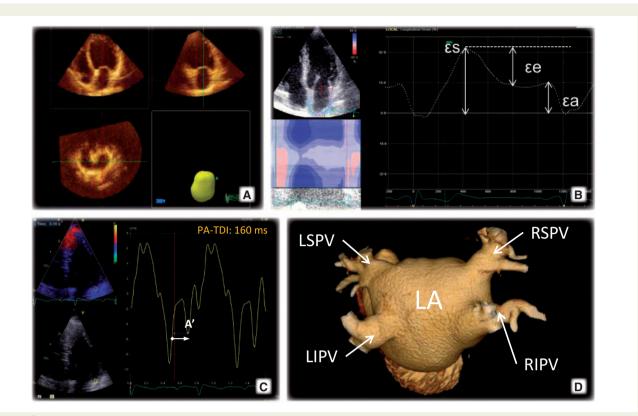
Multi-modality imaging to support rhythm control of AF. Assessment of left atrial volume (*A*) (real-time 3D transthoracic echocardiography), function (*B*) (2D speckle-tracking echocardiography, from which the longitudinal strain of the LA can be measured and the reservoir (ɛs), conduit (ɛe), and booster pump (ɛa) functions derived), fibrosis (*C*) (time interval between the onset of the P-wave and active atrial contraction measured with tissue Doppler imaging, PA-TDI), and pulmonary vein anatomy (*D*) (computed tomography). LA, left atrium; LIPV, left inferior pulmonary vein; LSPV, left superior pulmonary vein; RSPV, right superior pulmonary vein.
